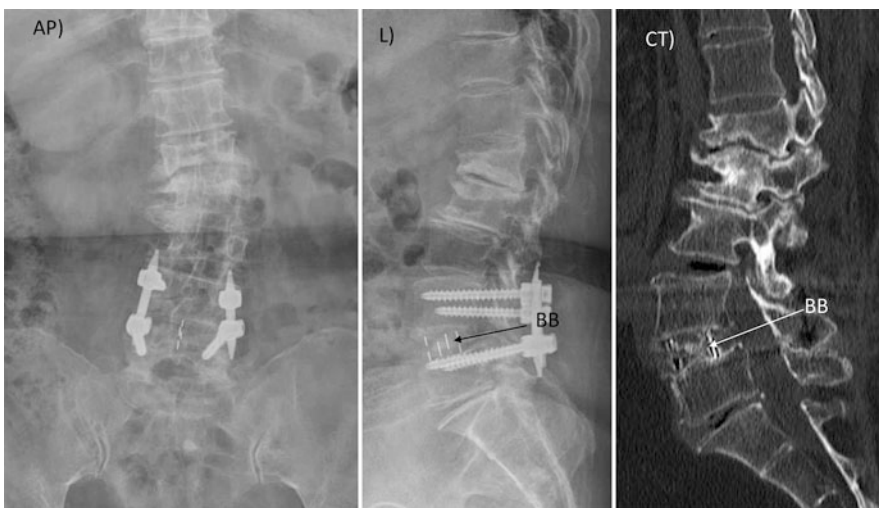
A 60-year-old female patient was surgically treated with a diagnosis of spinal-stenosis L4-L5. Surgery: an indirect decompression of spinal nerve and fusion via oblique interbody fusion (OLIF) technique with PEEK cage containing DBM-based product (Medtronic). A hemilaminectomy via MIS surgery technique was performed using percutaneous screw fixation. On anterior-posterior (AP), lateral (L) radiographs taken at
